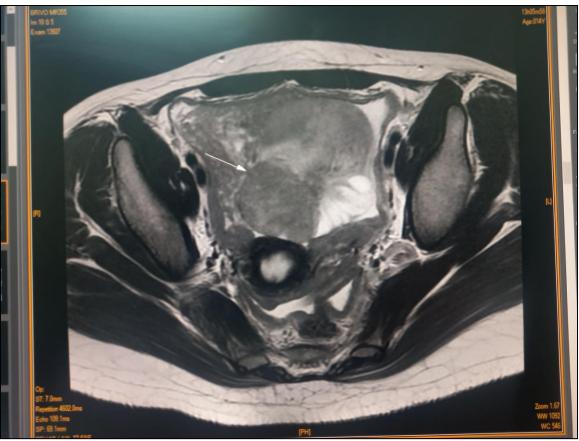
Pelvic MRI showing two bilateral ovarian masses
